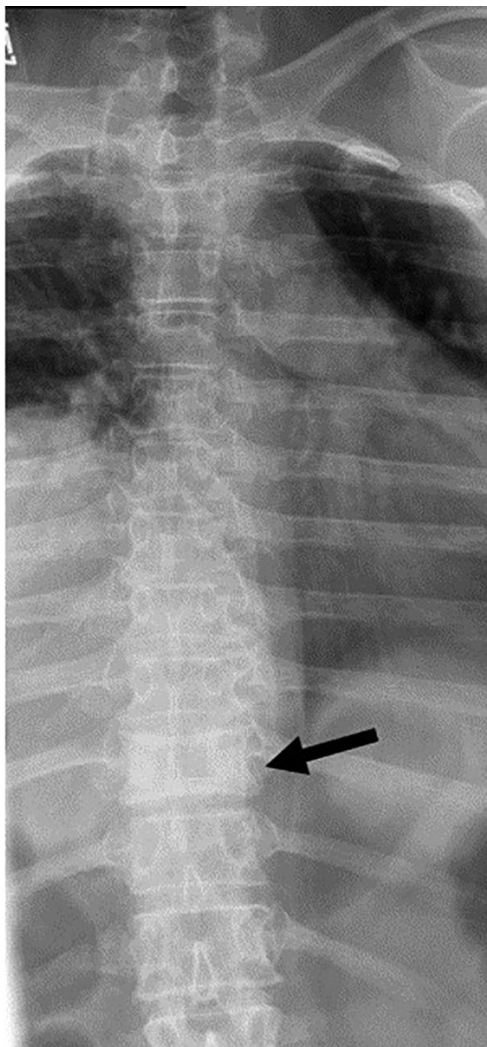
Skeletal X-ray of a 57 y-old woman with R155H associated myopathy and Paget disease reveals sclerotic changes and slight enlargement of the T10 vertebral body (arrow)
